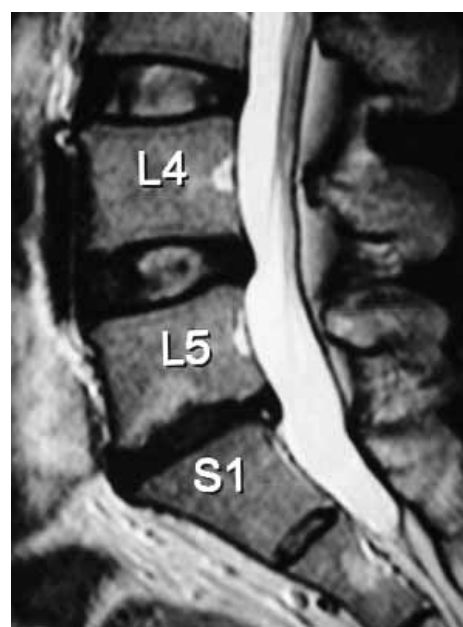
T2 weighted MRI image demonstrating a large left paracentral extrusion at L5S1 level.
